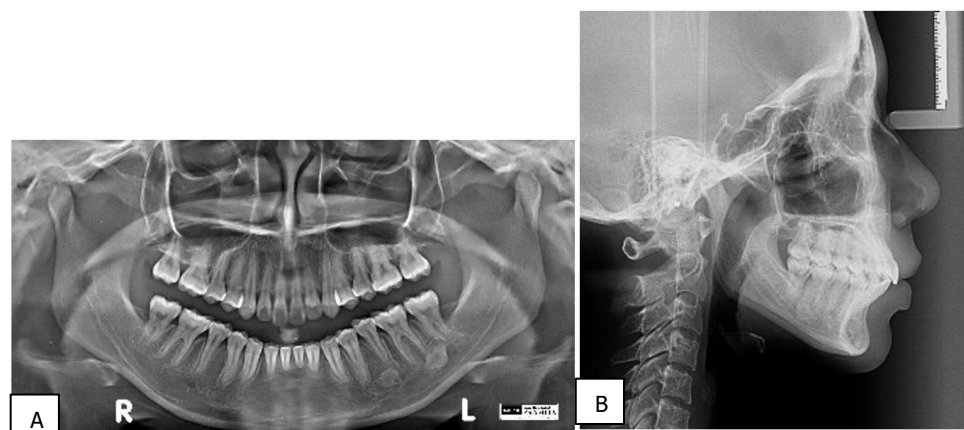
A. Post-treatment panoramic radiograph. B. Post-treatment lateral cephalogram radiograph.
